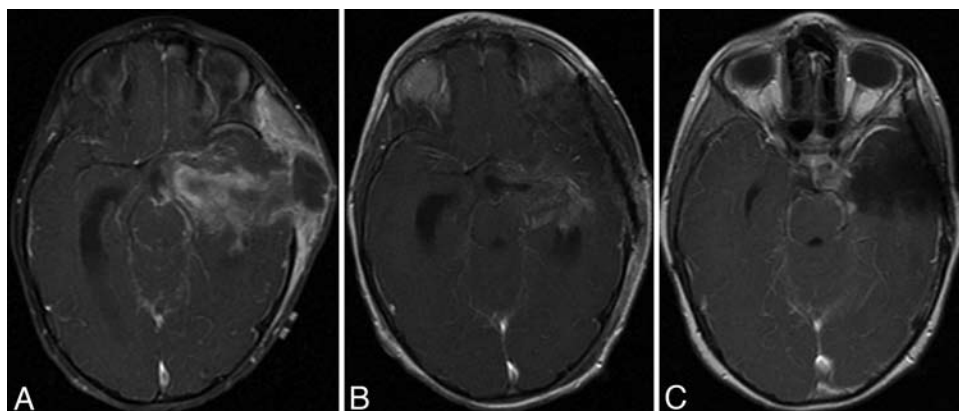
Contrast-enhanced, axial T1-weighted MR images obtained before the final resection (A), after final resection (B), and 9 months after resection (C).
